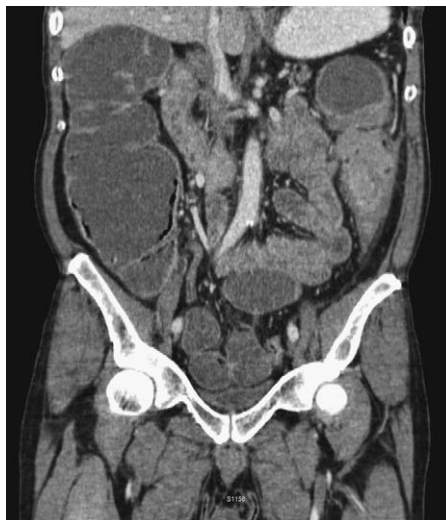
Coronal reformatting of CT scan in Fig. 2 reveals the cause of obstruction to be a mass in the descending colon.
